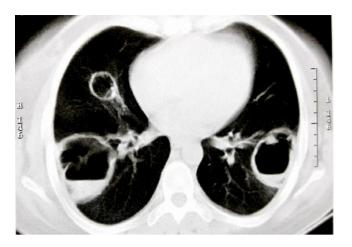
Chest computed tomography scans
